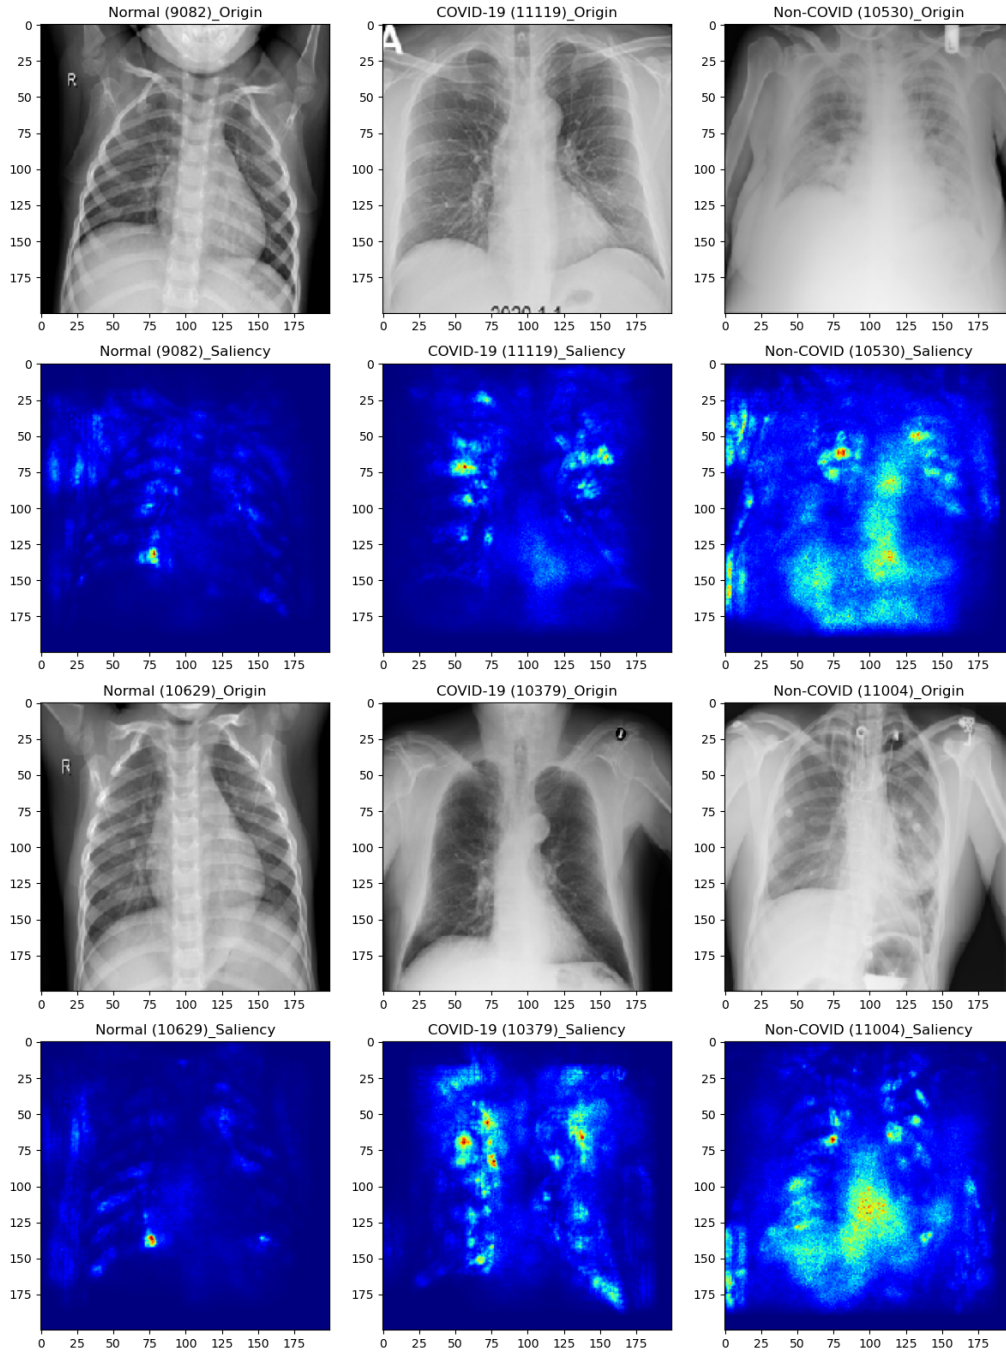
Chest X-ray images with corresponding predictions.
